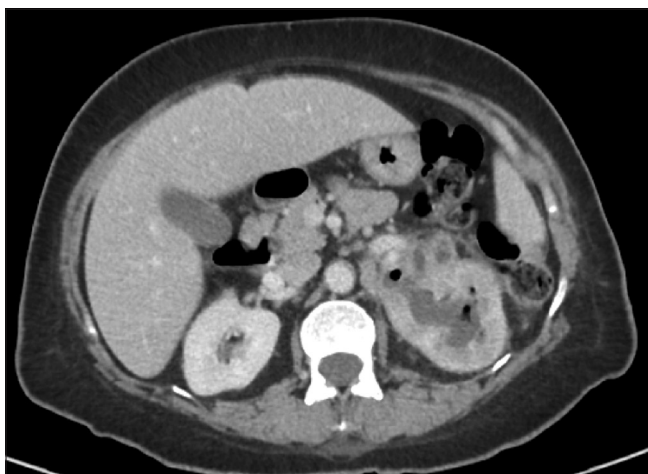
Abdominal computed tomography showing multiple air bubble foci within the collecting system of the left kidney
